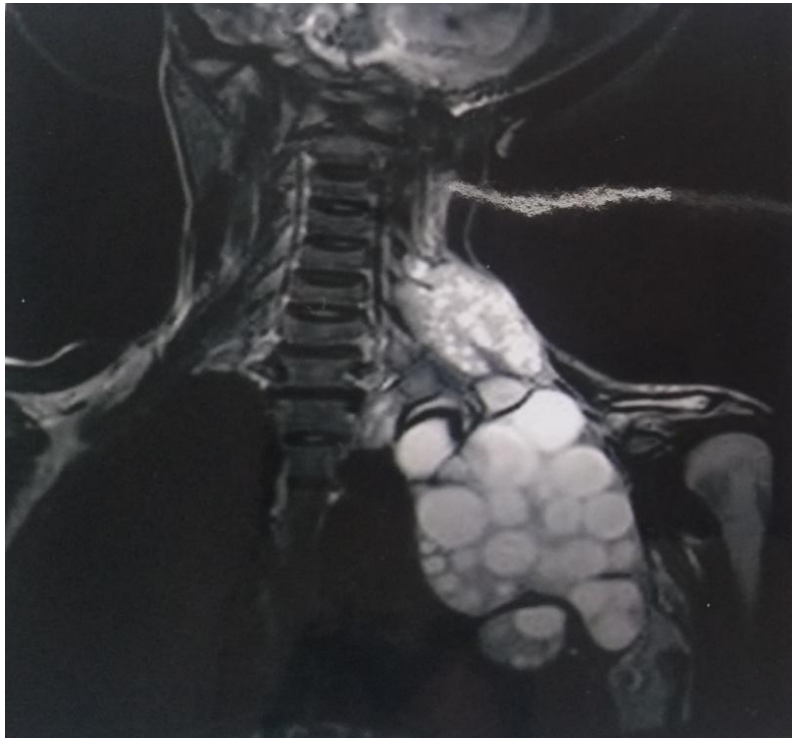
T2W coronal MRI image showing hyperintense daughter cysts in a case of extra pulmonary hydatid cyst.
